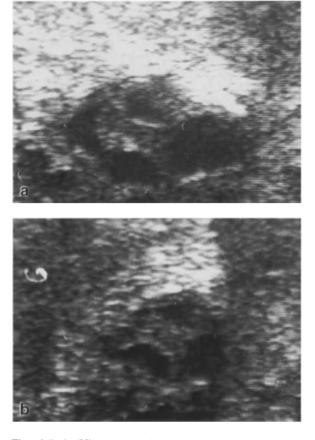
Ultrasonography of the seminal vesicles, in a patient with several cysts. a Right seminal vesicle; b left seminal vesicle
